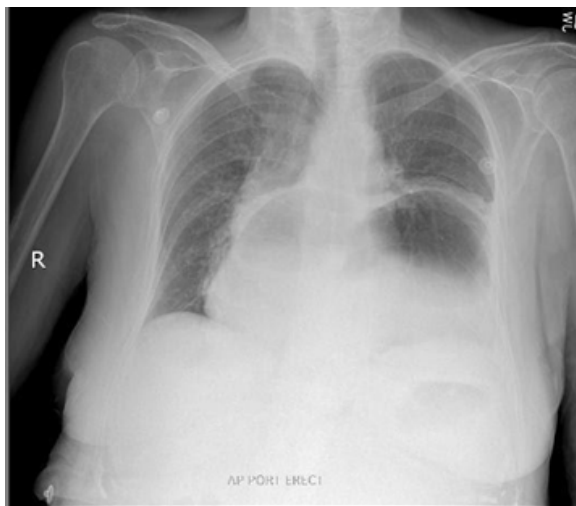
Chest X ray showing large hiatal hernia, CT was suggested to confirm gastric volvulus
